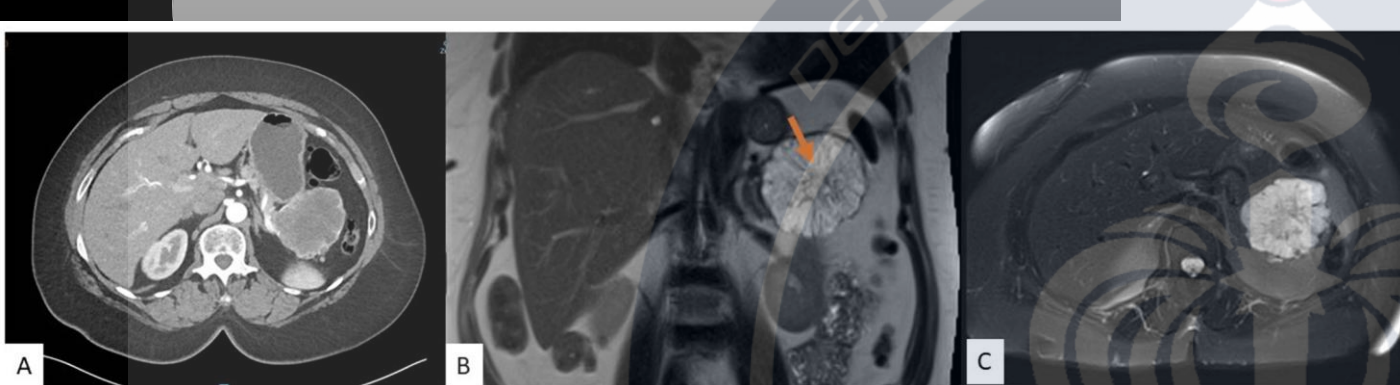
A 54-year-old female with an incidental pancreatic cyst. CT image showing a heterogeneously enhancing lesion with numerous small internal cysts in the tail of the pancreas measuring 6.4 cm × 7.3 cm × 5.4 cm (AP × TV × CC) (A). MRI coronal (B) and axial (C) views of a microcystic lesion in the tail of the pancreas with enhancing septations and central scar (arrow).
